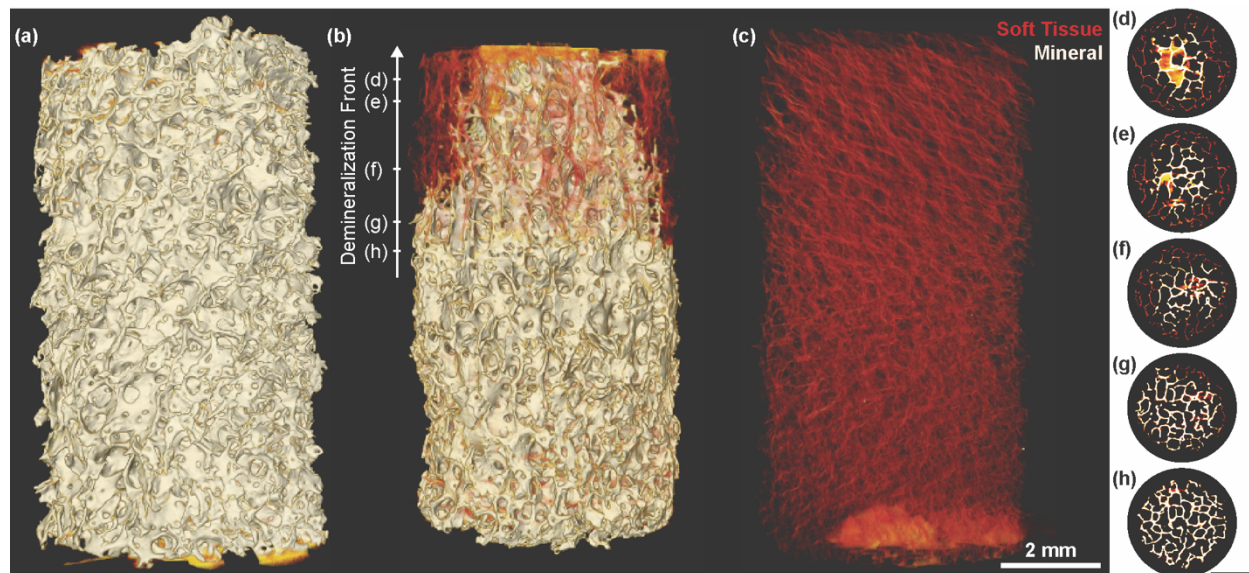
X-ray μ CT of interfacial scaffolds showing demineralization front morphology. High densities are shown in white (mineral), and lower densities are shown in yellow and red (collagen). (a) Fully mineralized bone biopsy prior to submersion in demineralization solution. (b) Interfacial scaffold after half submersion for 4.5 hours in demineralization solution. Demineralization front forms conical profile as demineralization progresses. (c) Fully demineralized bone biopsy. (d – h) Single slices from μ CT of (b). Hash mark on Demineralization Front arrow in (b) indicates approximate location of each slice.
